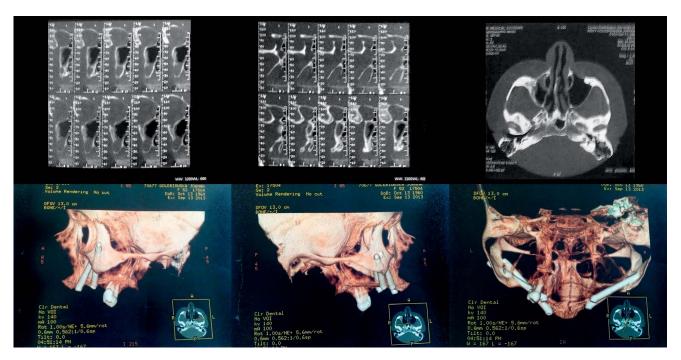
Pre- and post-zygoma procedure cone beam computerized tomography scans.
